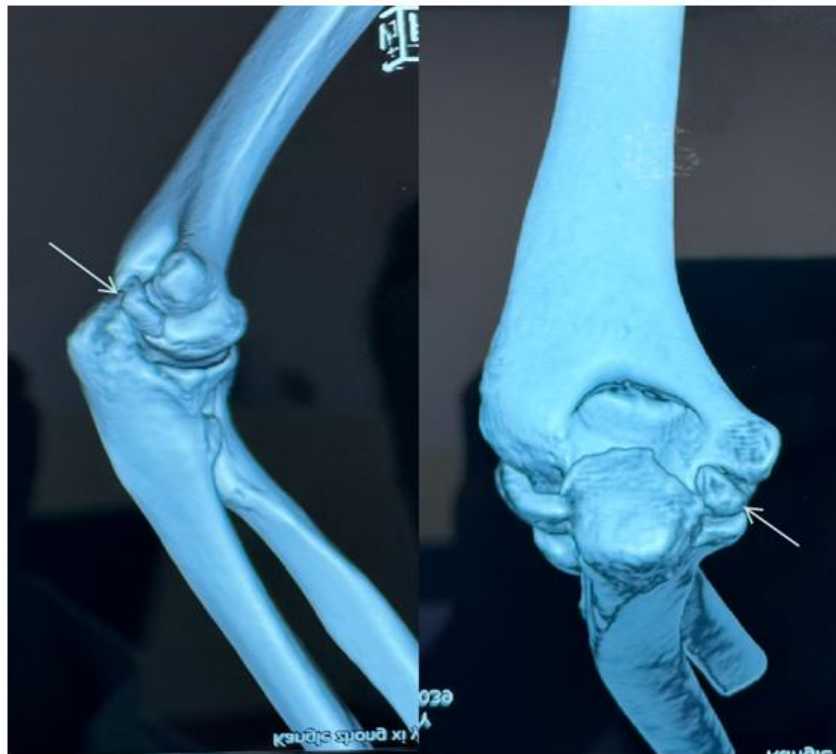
CT three-dimensional reconstruction. white arrow pointing to the position of free bone
